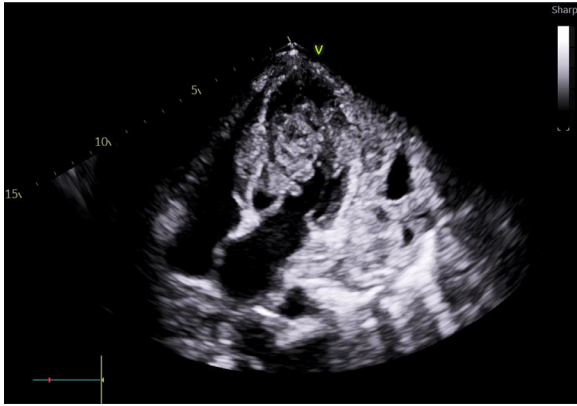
2D echocardiogram showing space occupying mass in the left ventricular cavity and pleural effusion with similar mass lesion.
